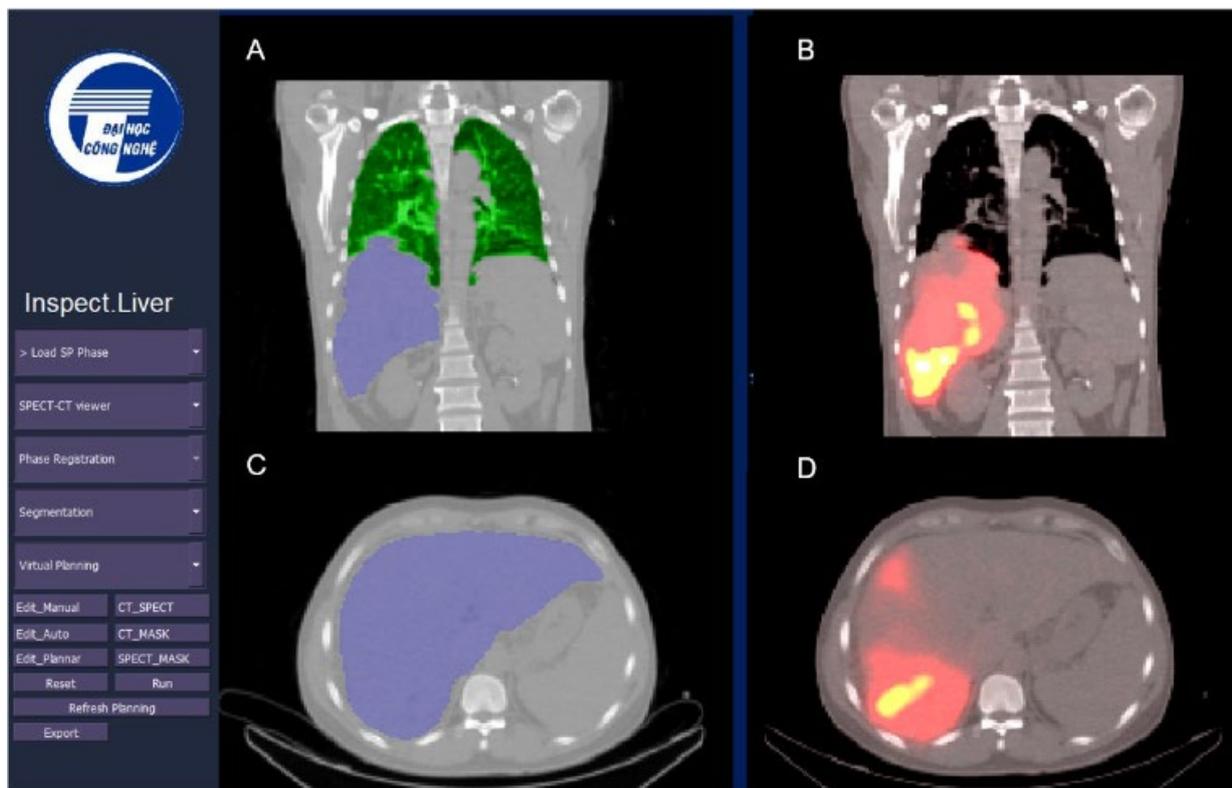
Estimation LSF% by automated CNN- based segmentation. Definition of liver and lung ROIs on sagittal imaging (A) correlated with fused $[^{99m}\text{Tc}]\text{MAA}$ and CT imaging (B). Recognition liver border on CT image (C) in comparison with fused $^{99\text{mTc}}\text{-MAA}$ and CT imaging (D).
